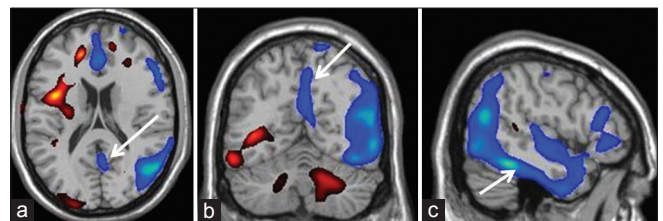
(a) Statistical parametric mapping t map of this case superimposed on a transaxial T1 MRI template image showing hypometabolism (blue colour) in left parietal and posterior cingulate cortices (arrow). (b) SPM t maps superimposed on coronal magnetic resonance imaging T1 template showing hypometabolism in left parietal cortex and precuneus (arrow). (c) SPM t maps superimposed on sagittal MRI T1 template showing hypometabolism in left temporal (arrow) and parietal cortices
